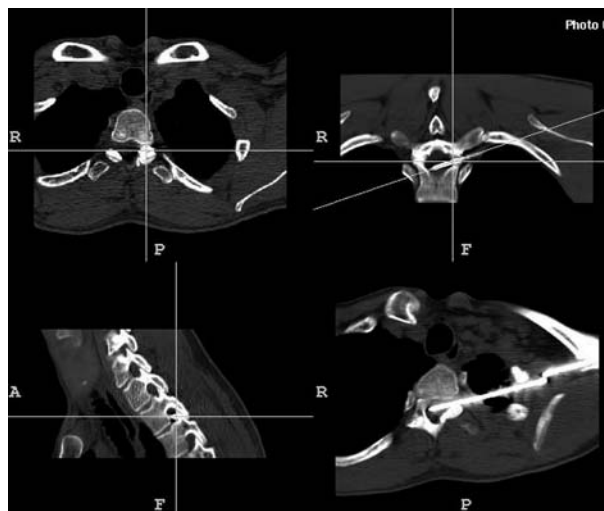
Thoracic spine CT scan : Transversal, lateral and oblique views showing the entry point of the K-wire into the dura and its transversal trajectory over the entire width of the spinal canal.
